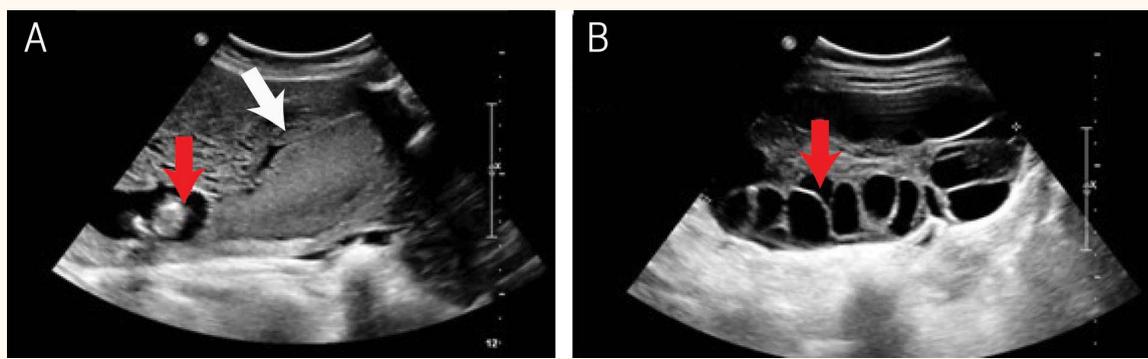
Ultrasound scans of a patient with a complete hydatidiform mole and coexisting live fetus showing (A) the junction between the normal placenta and the molar tissue (white arrow) and the normal fetus in the gestational sac (red arrow) and (B) the enlarged left ovary with multiple *theca* lutein cysts (red arrow).
